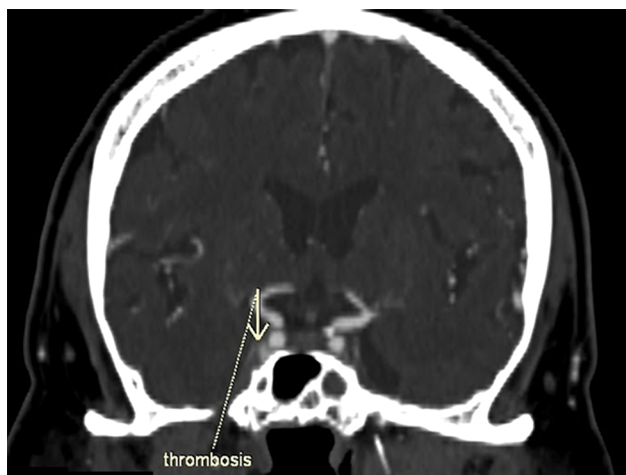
CT with contrast enhancement, coronal reconstruction. Thrombosis of the right sinus cavernosus.
